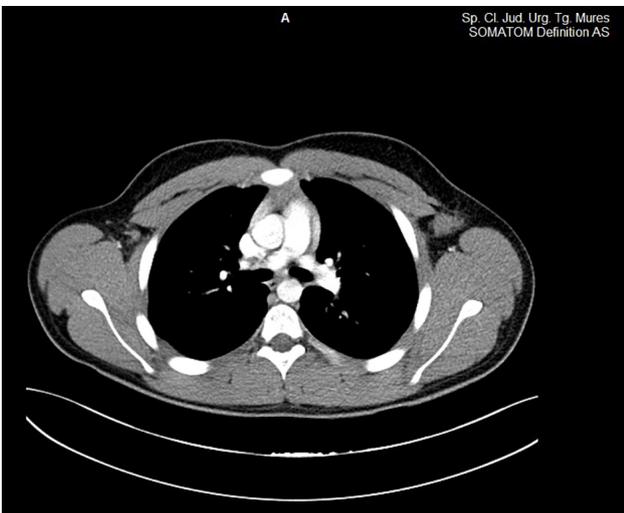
Thoracic CT angiography, axial section. Normal image of the thoracic aorta.
